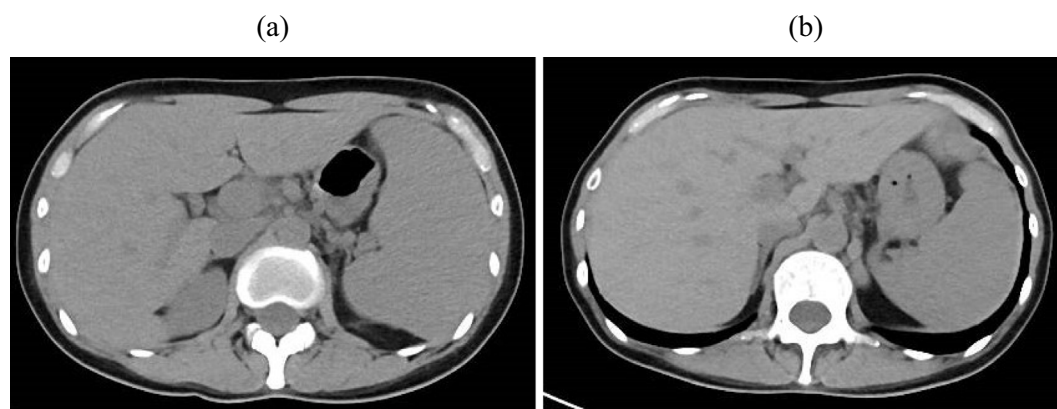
Computed tomography (CT) images at the diagnosis (a) and 32 days post-PSL treatment (b). The CT images showed some improvement in the patient's splenomegaly after PSL treatment.
